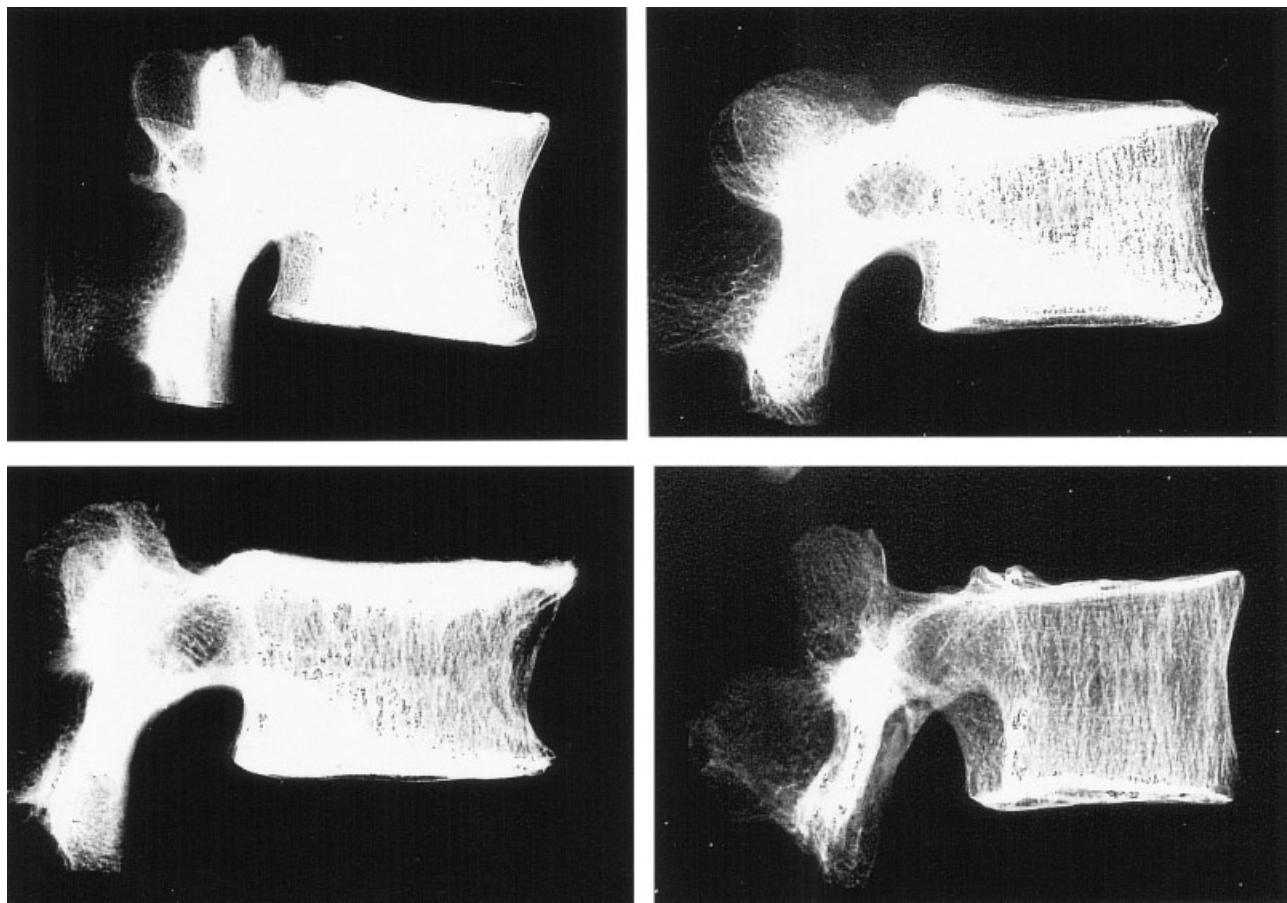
Radiographic patterns. Normal vertebra is shown in upper left corner; case with severe osteoporosis is shown in lower right corner. Other two cases show mild affection (upper right) and moderate affection (lower left).
